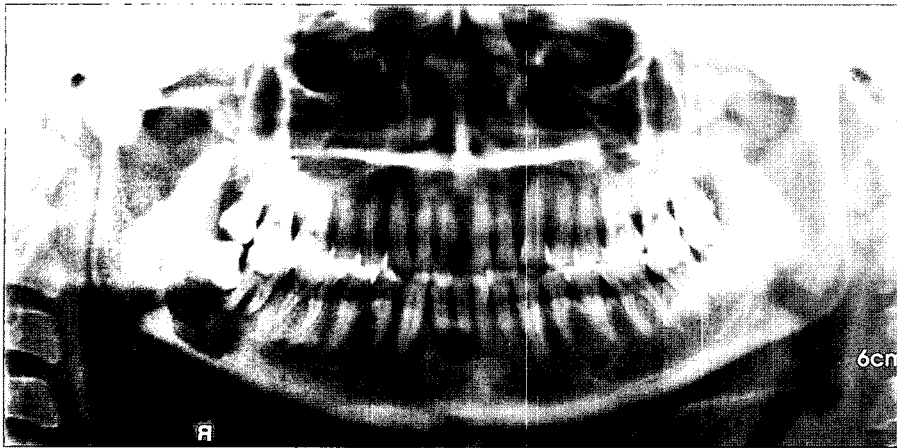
Panoramic radiograph shows unilocular radiolucency with poorly defined margin and infiltrative osteolysis in the right second and third molar region of the mandible.
